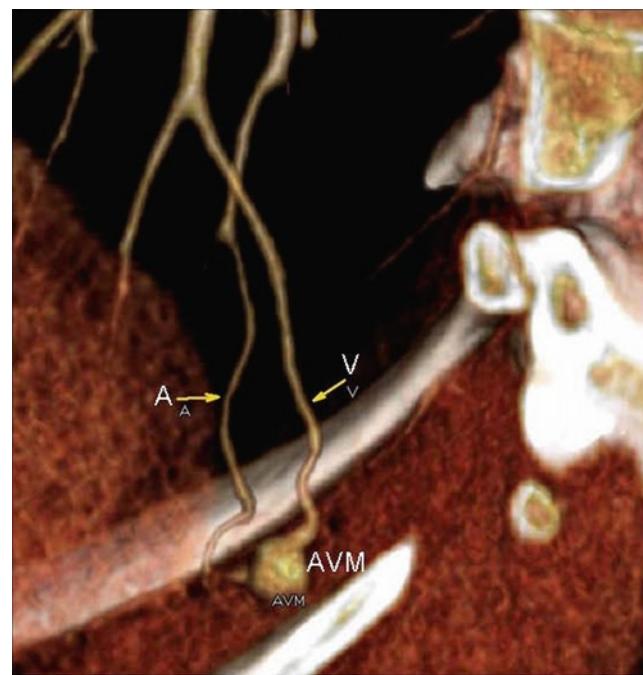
CT angiogram of a single pulmonary AVM in the right lower lobe. A feeding pulmonary artery; V draining pulmonary vein. This AVM is suitable for treatment by radiologic coiling (photo courtesy of Dr. Elsie Nguyen, Department of Radiology, Toronto General Hospital).
